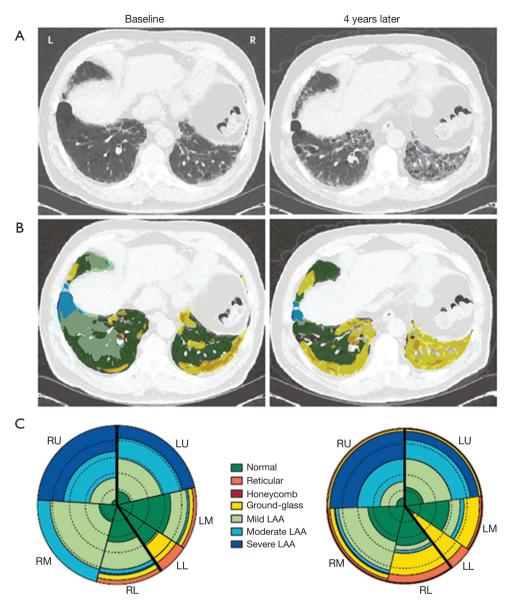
Local histogram-based (CALIPER) analysis of progressive lung fibrosis at baseline and 4 years later. (A) CT sections through the lower lungs show progression (left to right image) of the lung fibrosis; (B) CALIPER analysis with color coding according to CT pattern shows increase in extent of patterns characterized as ground glass abnormality (yellow) and a reduction in the extents of LAA (blue) and normal lung (green); (C) glyph-based analysis summarizes the extent of each pattern of abnormality in each lobe (the same color coding as in part B). The left lower lobe has decreased in volume. A relative increase is shown in extent of fibrotic abnormality (mainly yellow, orange, and red) and a decrease in normal lung (green) during 4 years (left glyph-based analysis to right). Reproduced with permission from reference (6). RU, right upper; LU, left upper; LM, left middle; RM, right middle; LL, left lower; RL, right lower; LAA, low attenuation areas.
